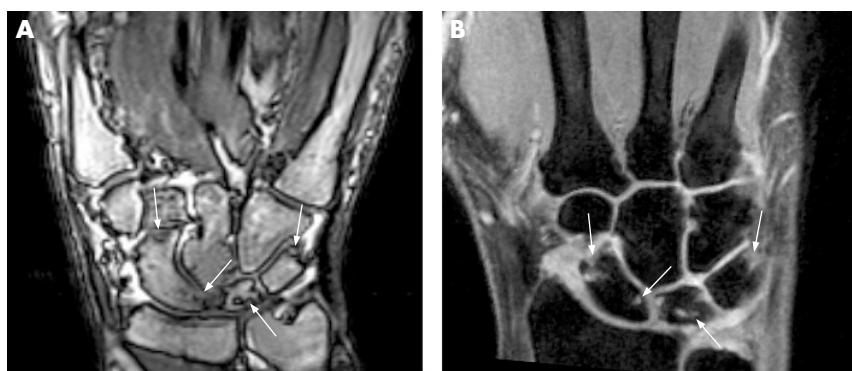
Comparison of erosions at the carpal bones in a 60-year-old patient with rheumatoid arthritis since 5 years. Gradient-echo sequence after contrast injection acquired by low-field MRI (A) and contrast-enhanced gradient-echo sequence with fat suppression (B) of the wrist show the same erosions at the scaphoid, lunate and triquetrum bones (arrows). In addition, mild synovitis is seen in both examinations, partly also within the erosions.
